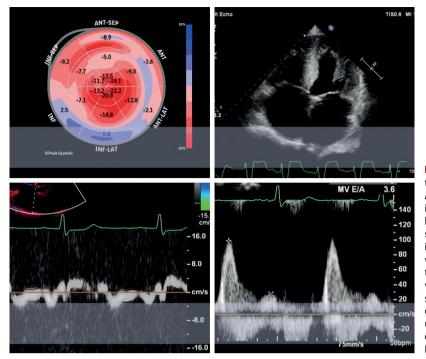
Echocardiographic findings in transthyretin amyloidosis cardiomyopathy. A. Speckle-tracking echocardiography showing the apical sparing pattern with preserved longitudinal strain in the left ventricular apical segments and impaired longitudinal strain in the basal segments. B. 4-chamber apical view: atrial enlargement as well as concentric thickening and granular structure of the left ventricle. C. Tissue Doppler imaging: reduced septal mitral annular velocity. D. Mitral inflow on pulsed-wave Doppler: grade 3 left ventricular diastolic dysfunction (source: Echocardiography Laboratory, John Paul II Hospital, Kraków, Poland)
